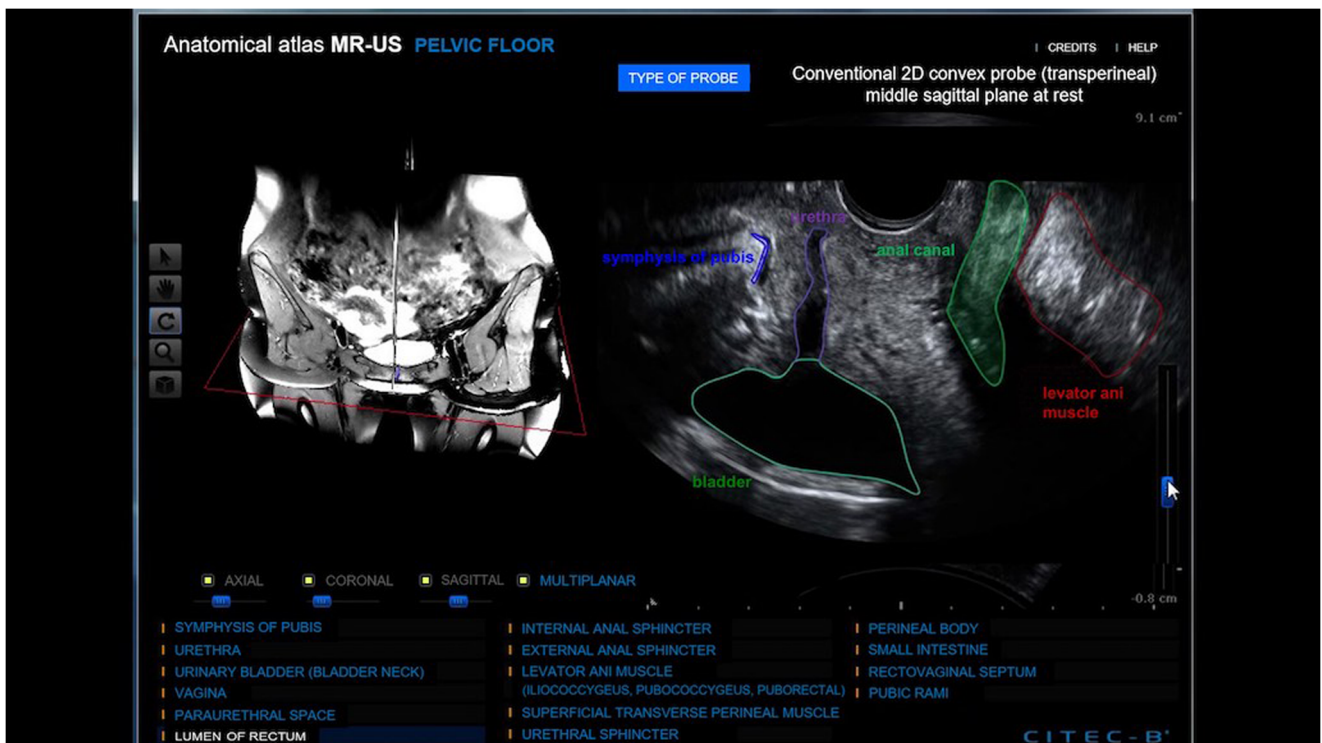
Screen of the anatomico-radiological viewer. The ultrasound image on the right shows the identification of the anatomical structures that can be recognized
